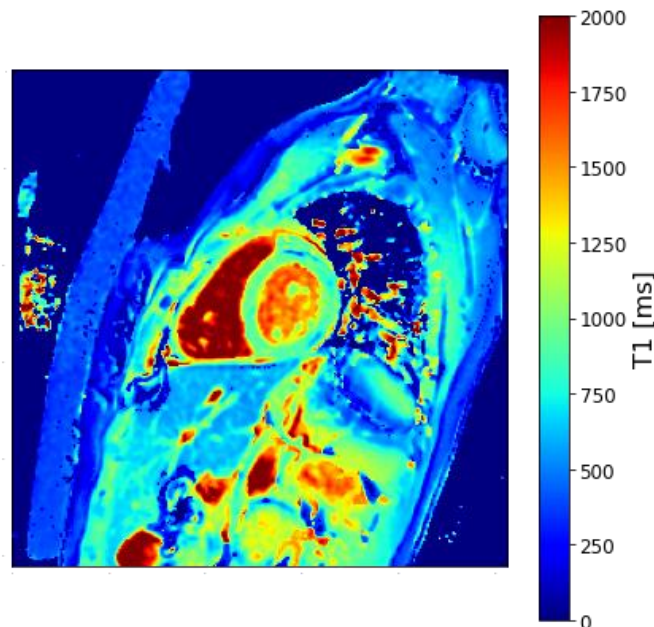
T1 map estimated from clinically acquired Magnetic Resonance Imaging sequence. Pixel color in the image indicates the T1 value in ms. Large T1 values (red) correspond to blood whereas medium values (yellow, green) correspond to the myocardium and other soft tissues and low T1 values (blue) correspond mostly to air.
